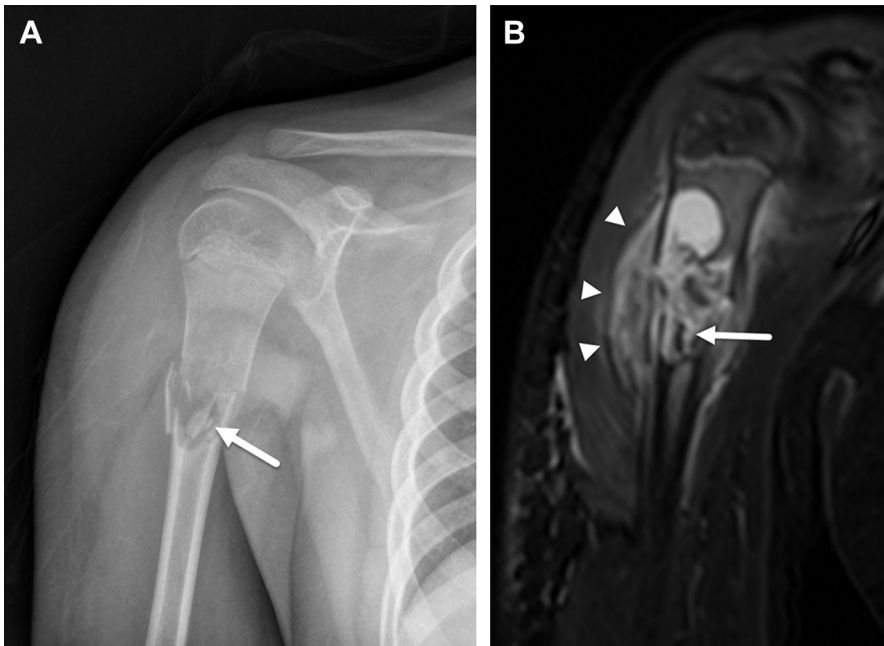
A 13-year-old boy with severe right upper extremity pain after fall. (A) Frontal view of the right shoulder shows comminuted pathologic fracture with small cortical fragment within a cystic bone lesion (*arrow*). (B) Coronal STIR MR image confirms the fallen fragment (*arrow*) within a unicameral bone cyst. A pathologic fracture and subperiosteal hematoma (*arrowheads*) are also noted.
